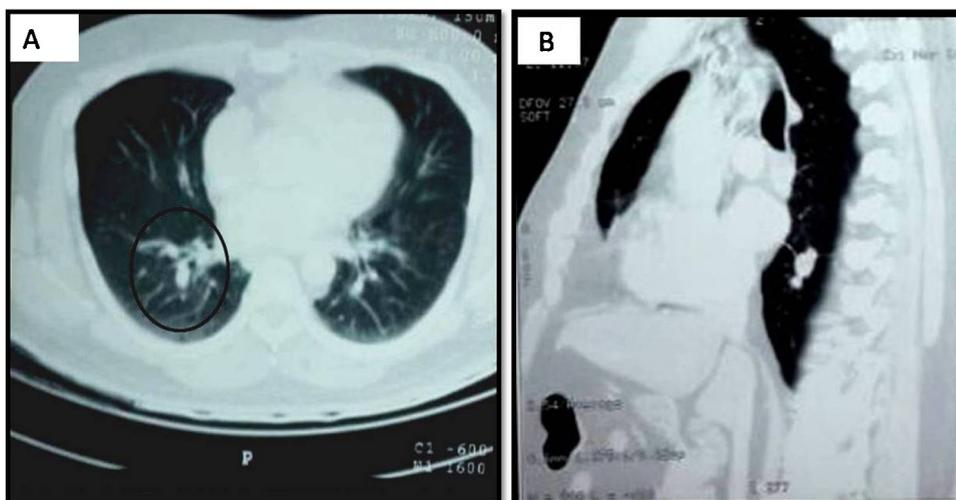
Computed tomography (CT) scan of thorax showing a parenchymal nodule in the lung (A – AP view and B – lateral view).
